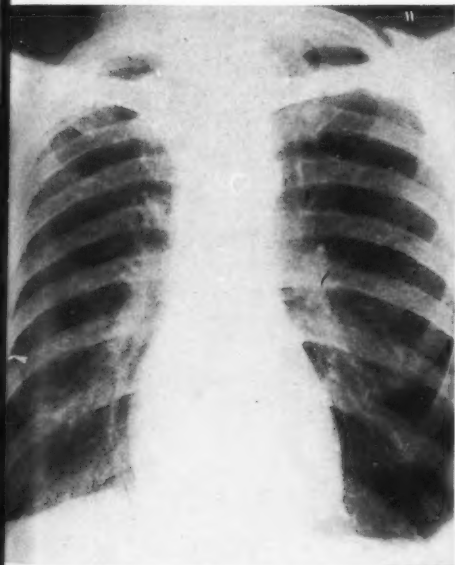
Radiograph of chest of steel moulder for 23 years (aged 37) showing increased linear striation.
